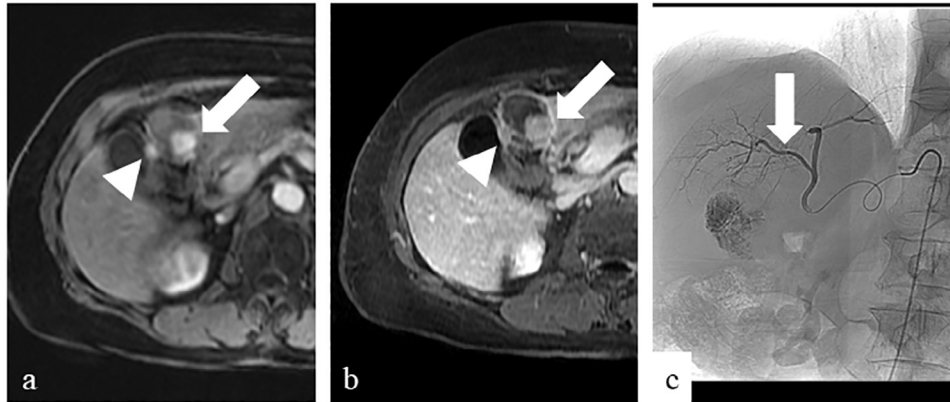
Interval magnetic resonance imaging (MRI) was performed of the lesion 12 weeks after the last MRI (a total of 17 weeks after transarterial chemoembolization treatment #1) to monitor for residual tumor viability. (a) Fat saturated T1 post-contrast sequence MRI shows 2.3 cm (arrow) and 1.1 cm (arrowhead) arterially enhancing lesions (previously 1.6 cm and 1.1 cm) with unambiguous evidence of washout on (b) delayed phase fat saturated T1 sequence. Highly suggestive of residual tumor viability, the patient was taken back for transarterial chemoembolization (treatment #2). (c) Digital subtraction angiography depicts the left hepatic artery and selection of the medial segment (arrow) for intra-arterial treatment.
